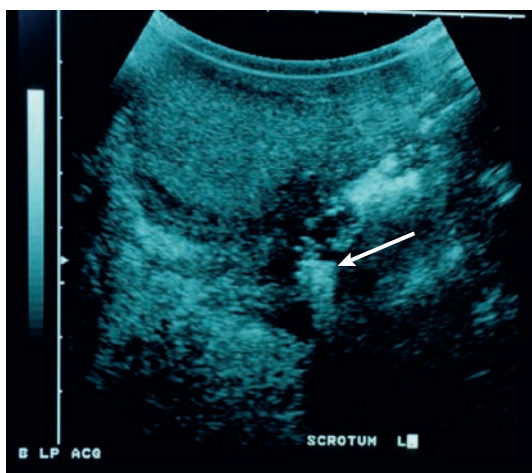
Ultrasonography of the scrotum of a patient with Fournier's gangrene. The pocket of echogenic gas is clearly visible (white arrow) and is indicative of a necrotizing soft-tissue infection with a possible anaerobic, gas-forming organisms.
